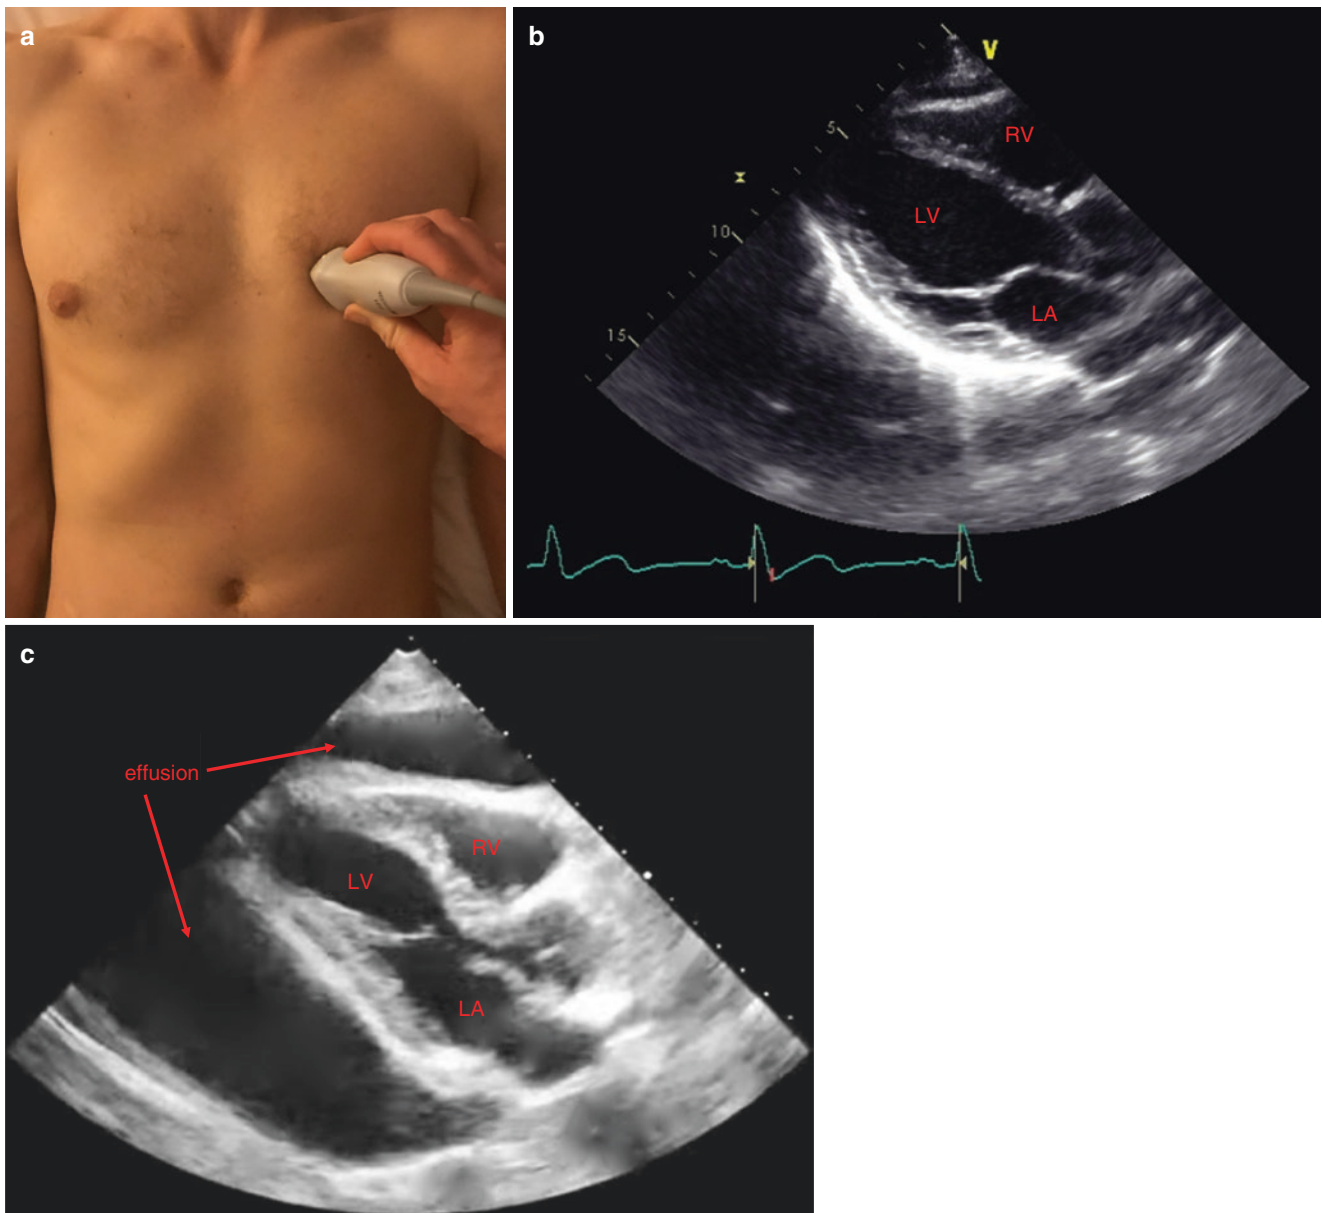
(a) Parasternal probe position (long axis). (b) Normal ultrasound image parasternal (long axis) view. (c) Parasternal view with pericardial effusion
